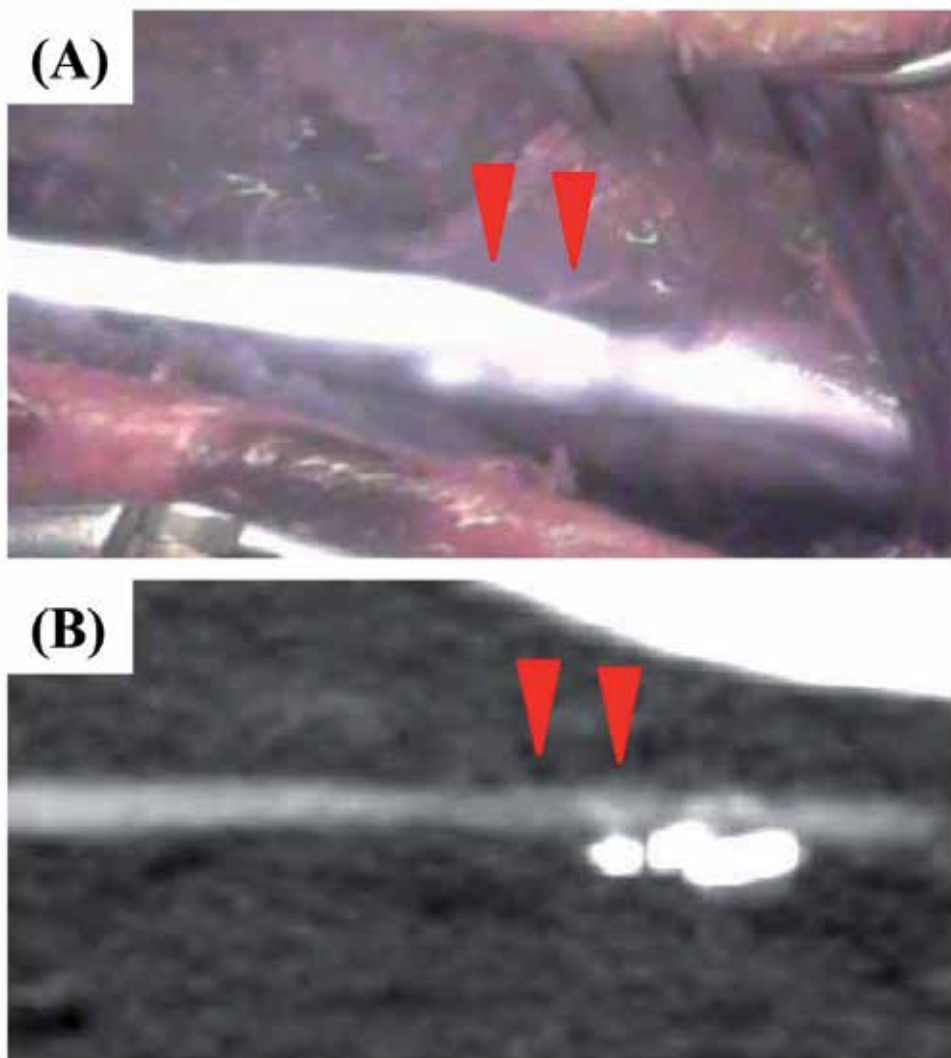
Intraoperative ICG angiogram compared with postoperative CT angiogram. The patient underwent femoro-tibial arterial bypass with saphenous vein graft. A: ICG angiogram of femoro-tibial arterial bypass with saphenous vein graft. Blood flow through the anastomosis is smooth. B: The CTA showed there was no anastomotic stenosis.
